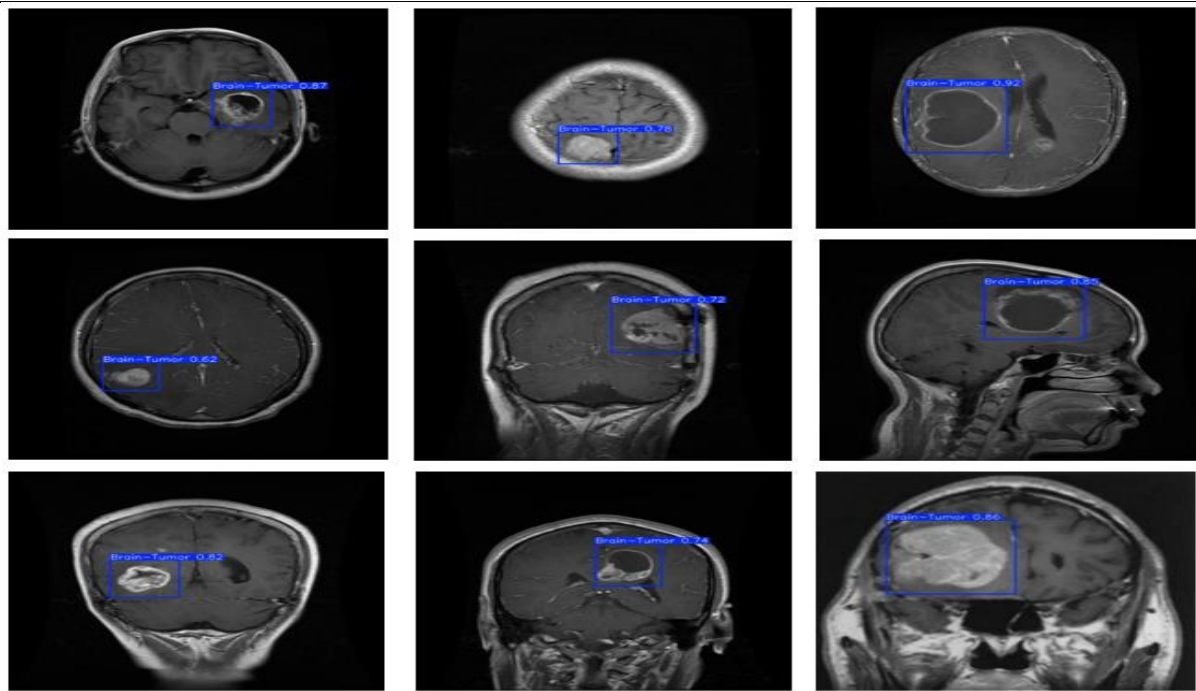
Detection Results of Brain Tumors in MRI Images using YOLO-v9 to YOLO-v11
